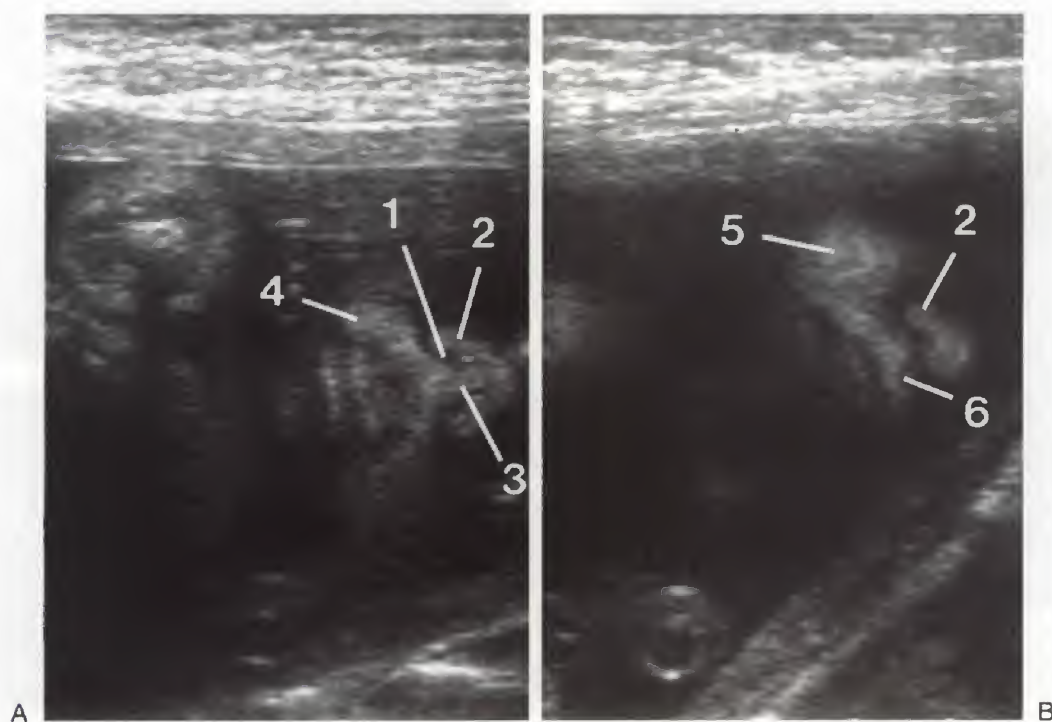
"Coronal" sonogram of the nose and mouth. Nasal structure is particularly well seen. 1, ala; 2, column; 3, nostril. The mouth displays less detail, although consistent and characteristic layering of echoes is seen. These layers are (presumably) the subcutaneous fat (5) and muscular tissue (6), the orbicularis oris muscle, and (7) the mucosal tissue.
